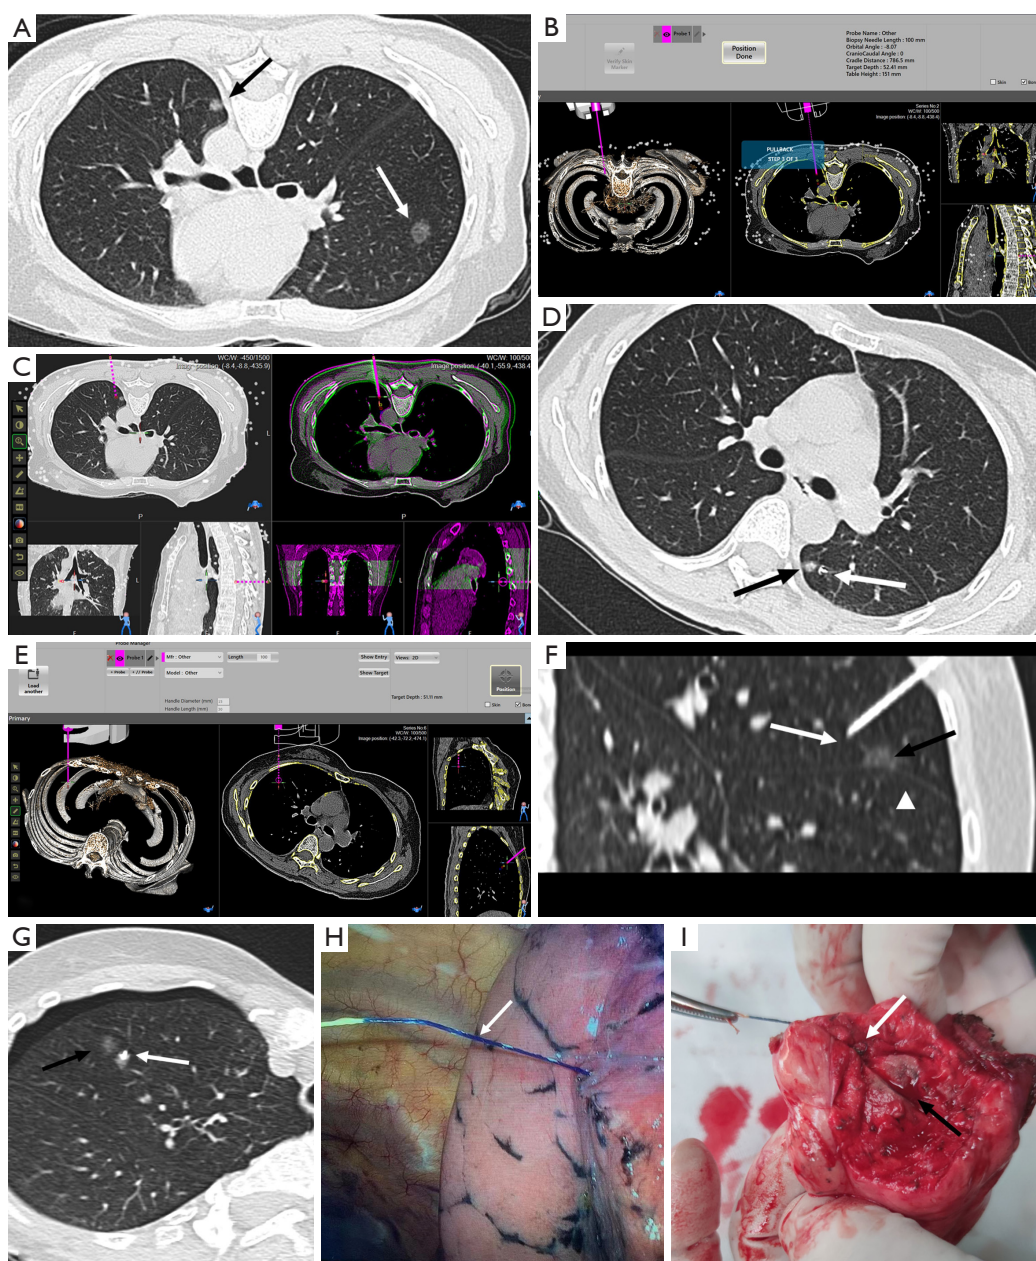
Example of two SPNs in the bilateral lungs undergoing robotic-assisted CT-guided localization. (A) A 10 mm pure GGN (white arrow) in the right upper lobe and a 6 mm mixed GGN (black arrow) in the left lower lobe need to be marked before VATS. (B) At first, the patient is placed in the prone position and the operator works out the puncture plan for the mixed GGN in the left lower lobe at the interface of the robotic assistant CT guidance system. (C) The image fusion of the planned scheme and the actual needle position shows only a small deviation. (D) Subsequently, post-localization CT shows the anchor (white arrow) is adjacent to the SPN (black arrow) and pneumothorax does not occur in the supine position. (E) The operator works out the out-of-plane puncture plan for the pure GGN in the right upper lobe at the interface. (F) Just like the planned scheme to avoid interlobar fissure (arrowhead), the needle tip (white arrow) is placed near the SPN (black arrow) and bypasses the interlobar fissure. (G) The last CT shows the anchor (white arrow) is adjacent to the SPN (black arrow) and mild pneumothorax and mild parenchymal hemorrhage occur. (H) During the VATS, the suture of needle (white arrow) accurately guides surgeon to locate the focus SPN. (I) The anchor claw (white arrow) and the marked SPN (black arrow) are displayed after VATS and its surrounding lung tissue. SPN, small pulmonary nodule; CT, computed tomography; GGN, ground-glass nodule; VATS, video-assisted thoracoscopic surgery.
